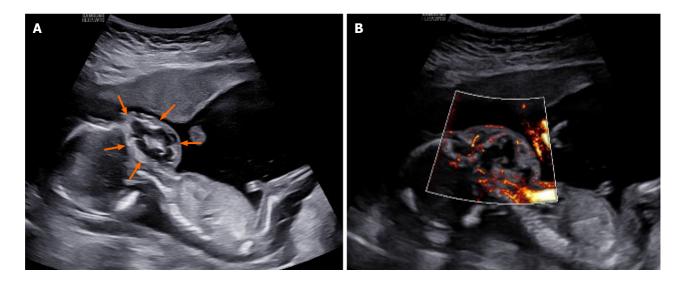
Prenatal ultrasound of an orofacial teratoma at 16 weeks of gestation (case 2). A: Cystic-solid echo of the fetal face (orange arrow); B: Microvascular flow imaging superimposed on section A, showing slightly abundant blood flow signals in the interior.
